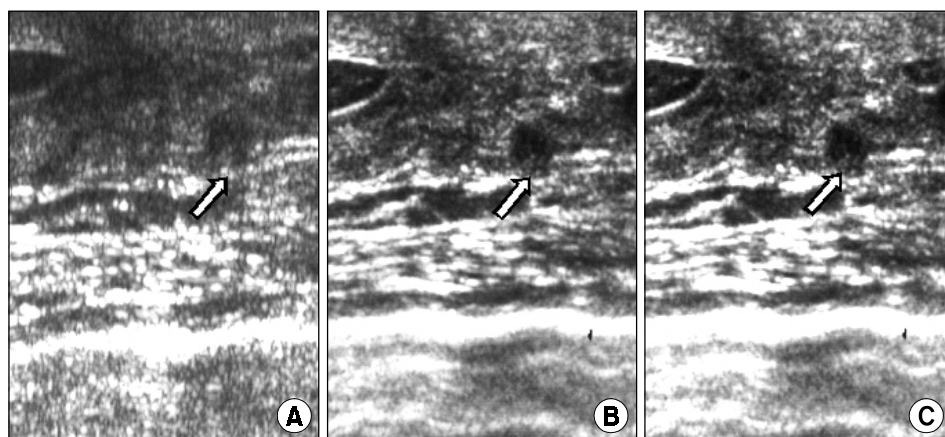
39-year-old female with intraductal papilloma. Ultrasonograms show a circumscribed round shaped isoechoic nodule (arrows) in subareolar area. In terms of clarity of margin and internal echoes of nodule, survey (B) and target (C) modes of RTCI are superior to conventional ultrasonography (A).
